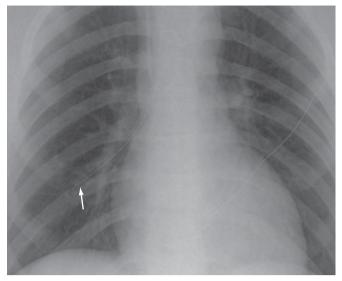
Follow tubes and lines to their tip: 17-year-old boy who is recently postsurgery. Chest radiograph demonstrates a nasogastric tube in a right lower lobe bronchus.
